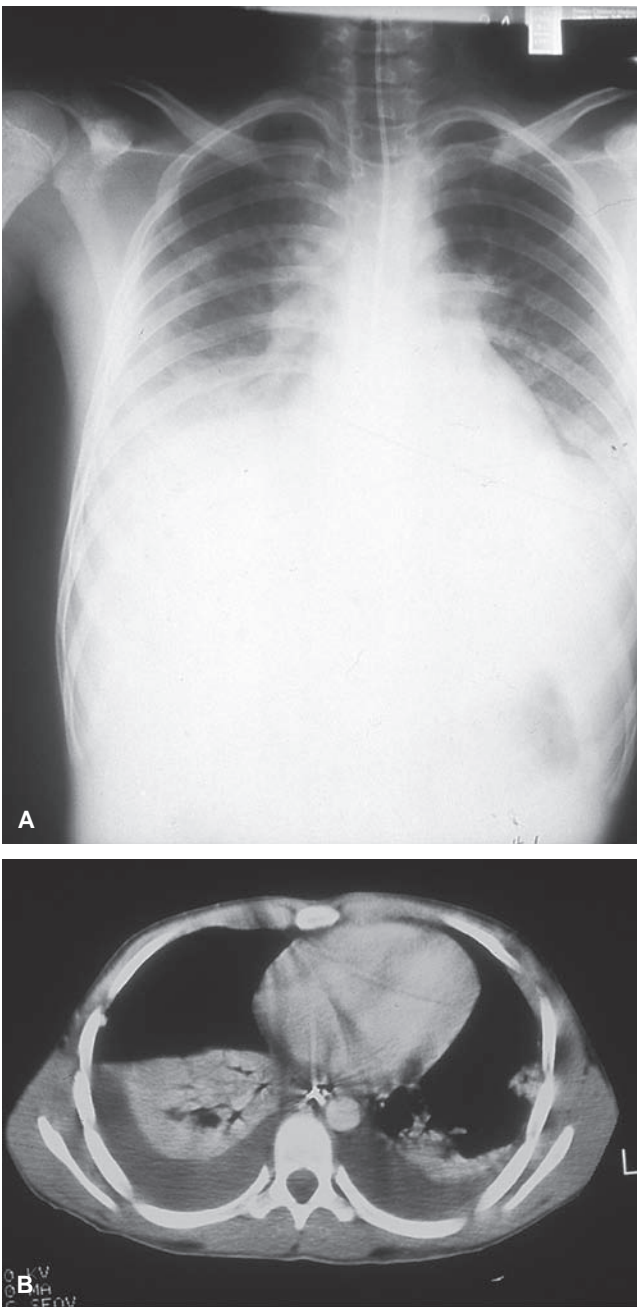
A 15-year-old child involved in an automobile–pedestrian accident. Vital signs were stable at the scene, but the child had decreased breath sounds bilaterally. A: Chest radiograph showed bilateral hemothorax and pulmonary contusions. B: Computed tomography confirmed and better delineated the hemothorax and pulmonary contusions.
